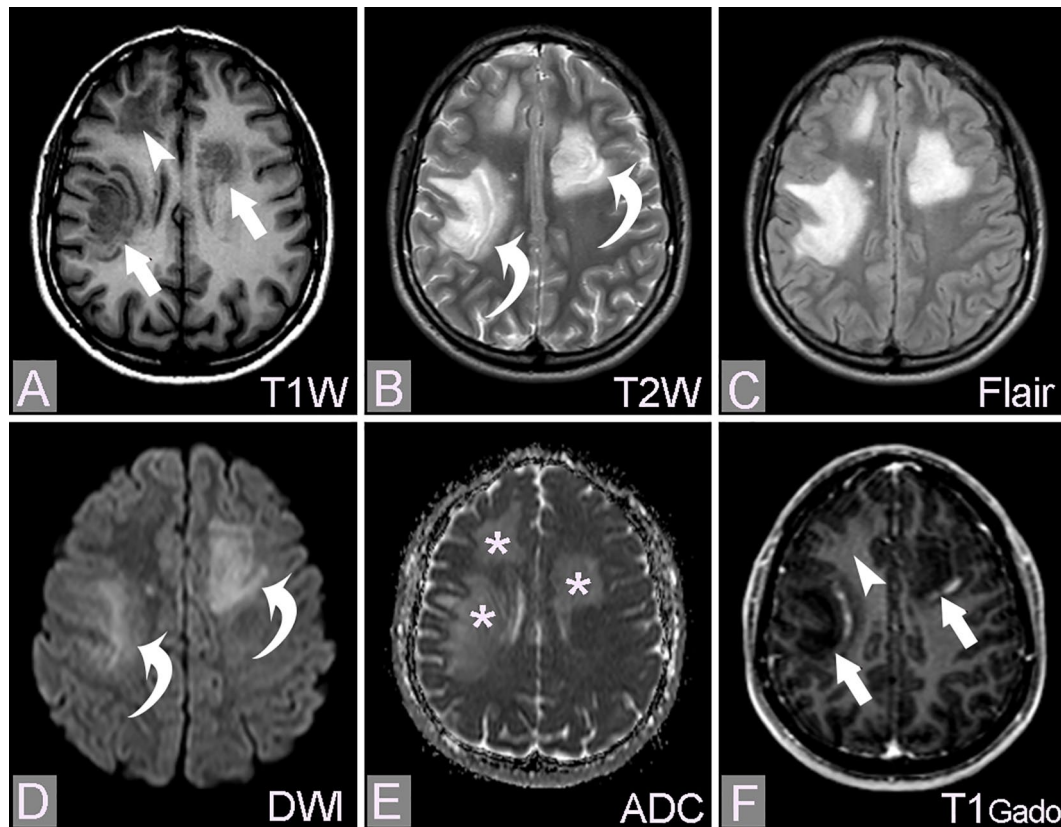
Pseudotumoral MS with typical lesions of BCS shows concentric lamellae (arrows), whereas more atypical Balo-like lesions display more complex shapes (head arrows): (A) T1W image shows hypointense lesions in the right frontal-parietal-temporal and left frontal, (B, C) lesions have a high signal intensity on T2W and FLAIR images, (D, E) lesions are unrestricted diffuse seen on the ADC image (asterisks). Note that the high signal intensity of lesions on the DWI image is an artifact due to T2 shine-through effect (curved arrows), and (F) a contrast-enhanced T1W image reveals a characteristic enhancement as a broken ring (arrows).
